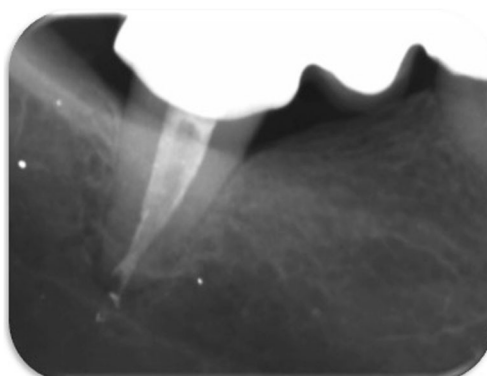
Case #2 radiographic assessment with a 12-month follow-up. To be noticed the complete regression of the AP and re-establishment of the bone structure around the mandibular nerve
